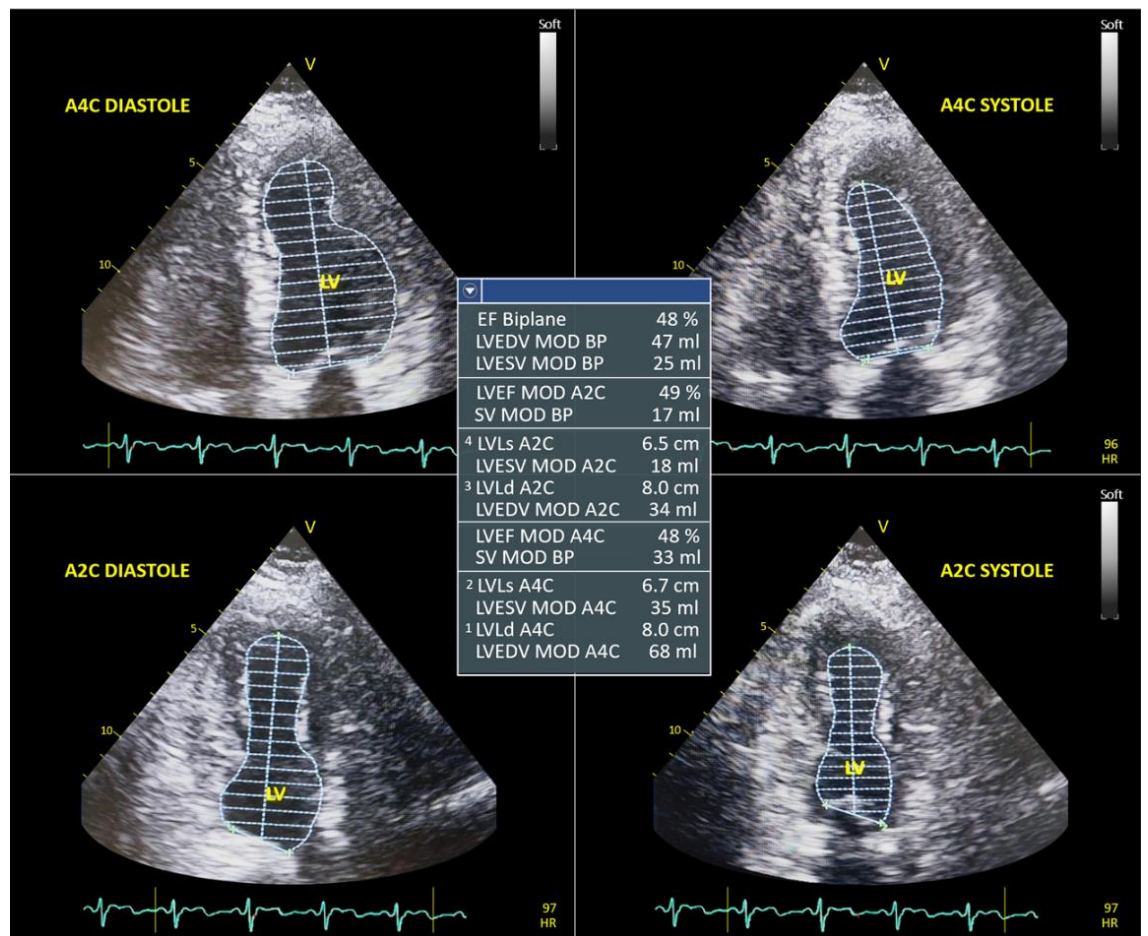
Transthoracic echocardiography (TTE) examination showed reduced left ventricular ejection fraction (LVEF) by biplane of 48%.
